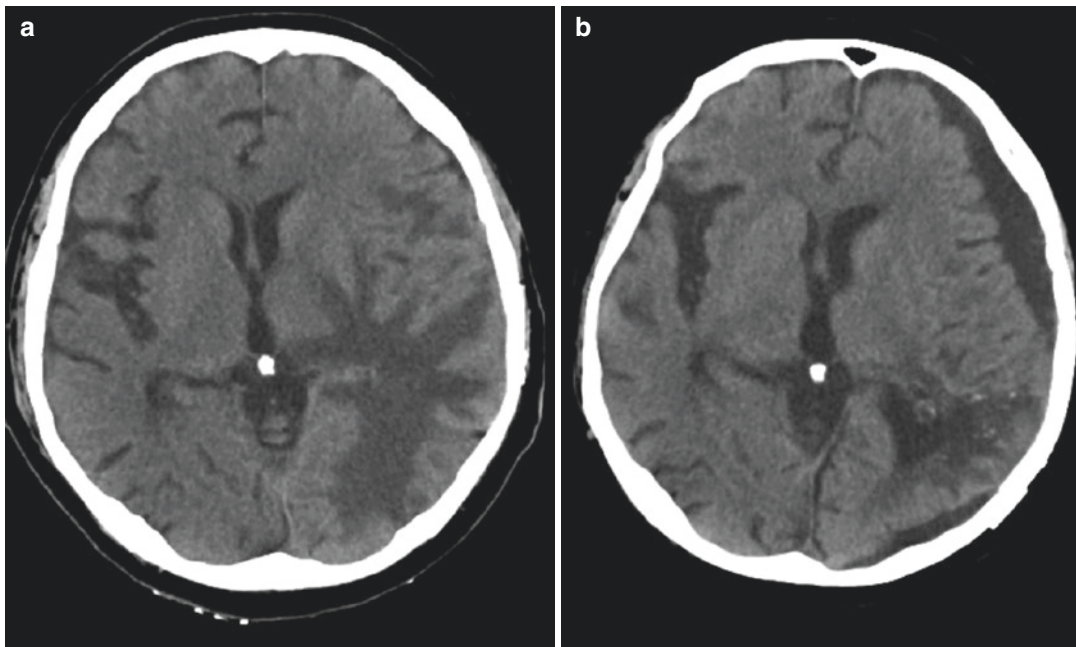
The images show development of cSDH in a patient with glioblastoma multiforme over a 10-month period, with the pre-operative CT image (a) and the post-operative CT image (b)
